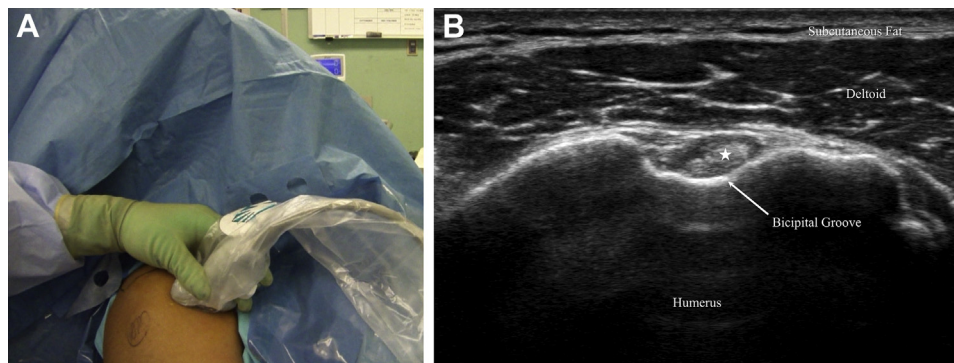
(A) External view of the linear ultrasound probe (M-Turbo), placed on the anterior aspect of the right shoulder with the patient in the beach-chair position, in short axis to the long head of the biceps tendon. The ultrasound is used to first identify the bicapital groove where the long head of the biceps rests. (B) Ultrasound image of the long head of the biceps tendon in short axis (star), resting in the bicapital groove. With the bicapital groove in view, placement of the portals and tenodesis in this location would be too proximal. The ultrasound probe can be scanned distally to identify the appropriate region for the suprapectoral tenodesis.
